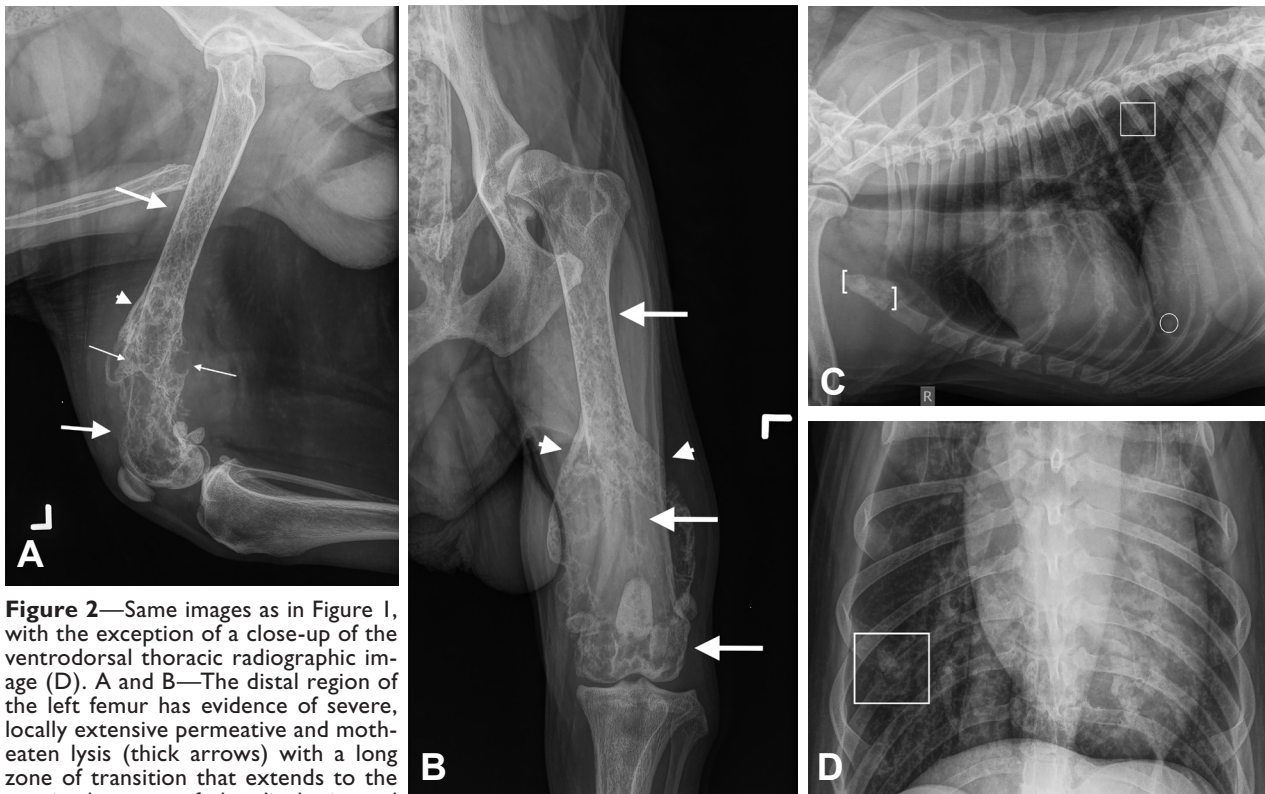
Same images as in Figure 1, with the exception of a close-up of the ventrodorsal thoracic radiographic image (D). A and B—The distal region of the left femur has evidence of severe, locally extensive permeative and moth-eaten lysis (thick arrows) with a long zone of transition that extends to the proximal aspect of the diaphysis, and there is moderate swelling of the surrounding soft tissue. The femur also has evidence of an expansile, solid, and relatively smooth periosteal reaction (arrowheads) distally and a pathological fracture (thin arrows) in the distal aspect of the diaphysis with mild craniocaudal displacement. C and D—The first sternebra has evidence of locally extensive, moth-eaten lysis and a faint amorphous periosteal reaction (brackets). There is a well-defined nodule (circle) in the area of the left caudal lung lobe. The proximal aspect of the right eighth rib has a focal lytic lesion with cortical thinning and expansion with interrupted periosteal reaction (square) evident on the ventrodorsal projection (D) but difficult to appreciate on the right lateral projection (C).
